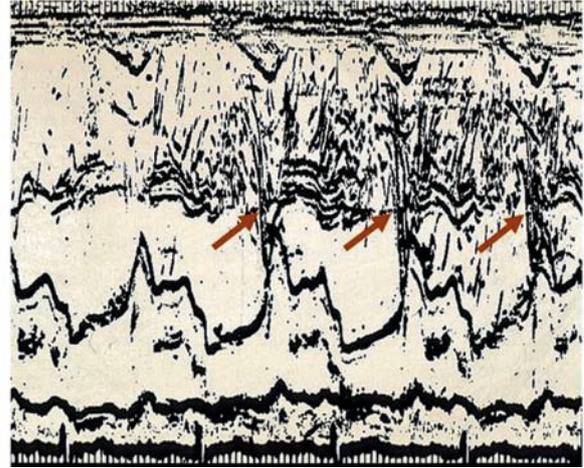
M-mode echocardiogram of a hand-agitated bubble contrast study in a patient with a large ventricular septal defect. Bubbles can be seen (arrowed) crossing from the right ventricle to the left secondary to bidirectional shunting
